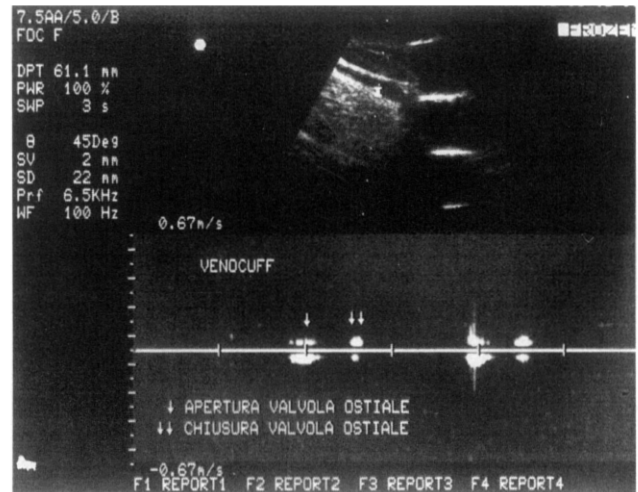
Duplex sonography after Venocuff application: demonstration of the valvular lock (↓ opening and ↓↓ closure of valvular ostium).
